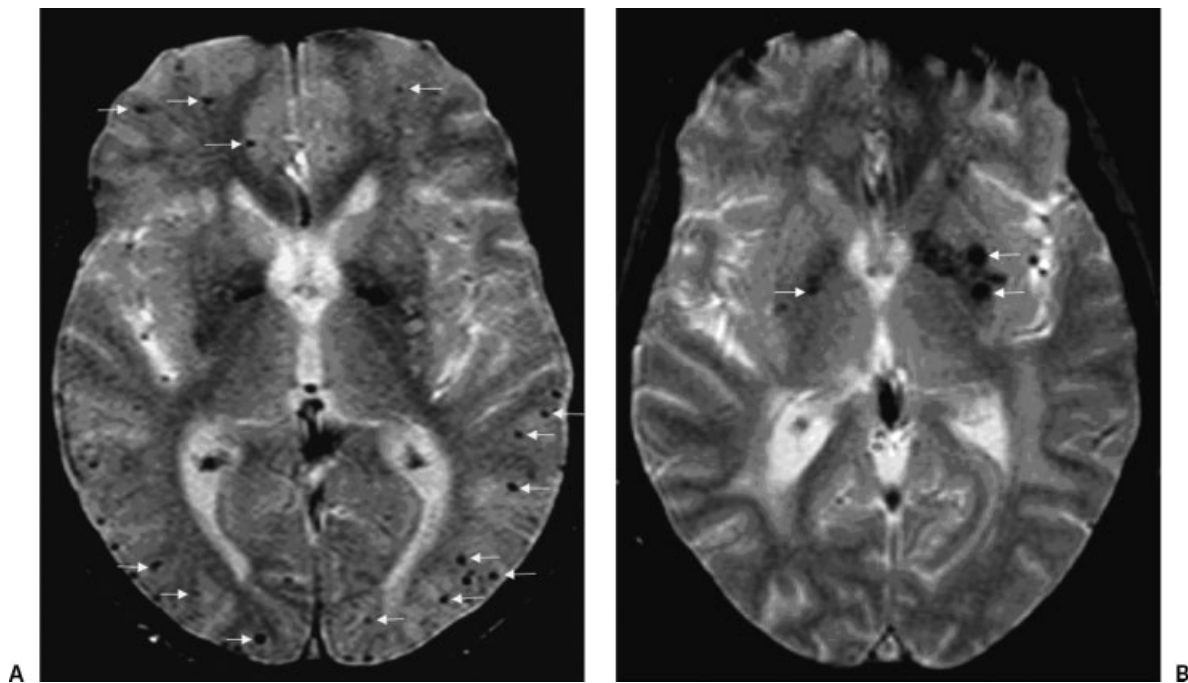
(A) A 73-year-old woman with a 2-year history of worsening cognitive function. Gradient-echo MRI shows multiple foci of signal loss in a cortical or lobar distribution (a subset of these lesions are demarcated by solid arrows). According to the Boston Criteria for diagnosis of cerebral amyloid angiopathy-related ICH, multiple strictly lobar or corticosubcortical hemorrhages, without other known cause, in a patient older than 55 are diagnostic of "probable cerebral amyloid angiopathy."⁸ (B) A 69-year-old woman with history of hypertension. Gradient-echo MRI shows foci of signal loss in bilateral basal ganglia (solid arrows). Deep microhemorrhages such as these are suggestive of long-standing hypertension.¹⁷
